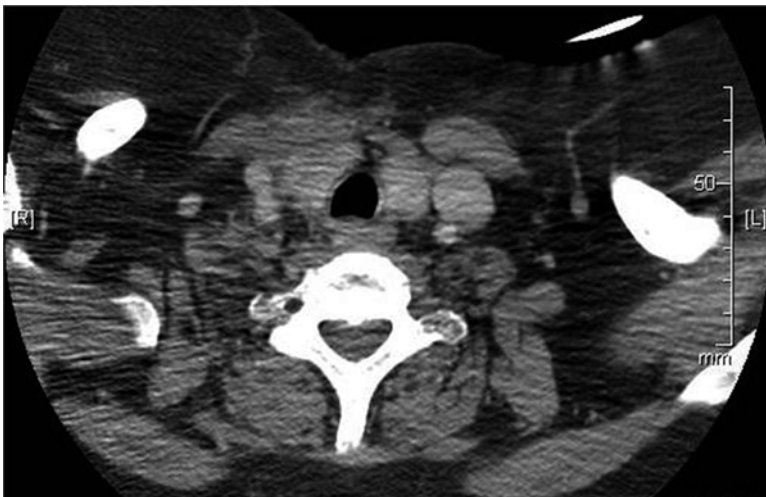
Posttreatment computed tomography scan of the soft tissues of the neck reveals no evidence of obvious residual disease
